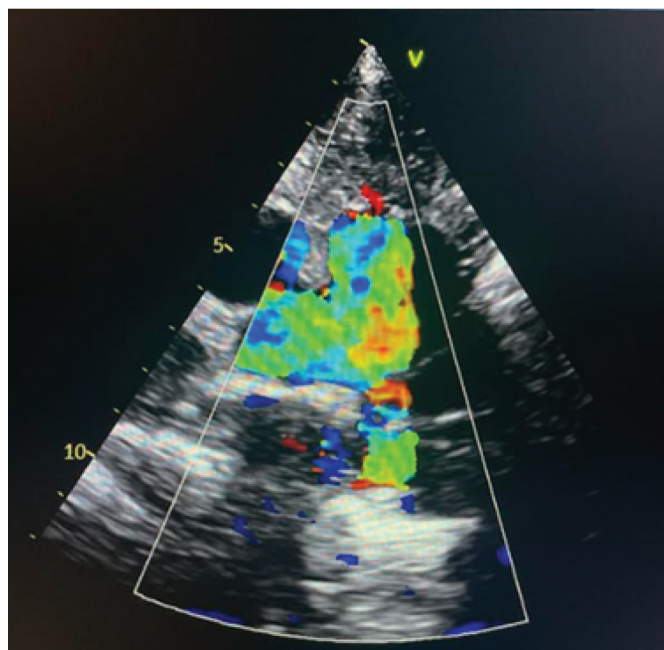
49-year-old woman: Color Doppler of the right ventricular outflow tract and branch pulmonary arteries in parasternal short axis view.
